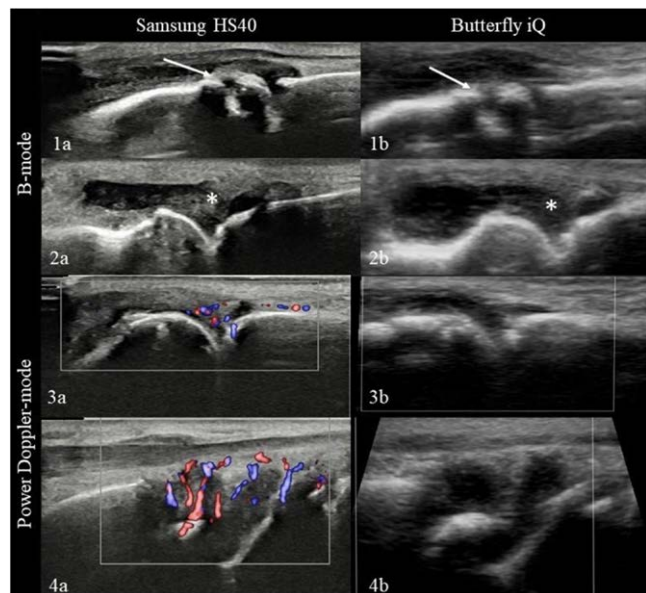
Pathological US findings in MCP joints (1, 2, 3) and wrist (4) depicted by the two different ultrasound devices
